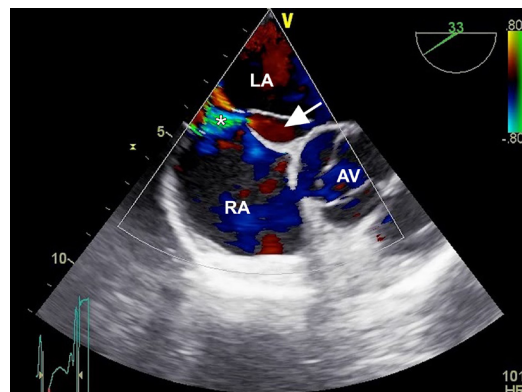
Two-dimensional transesophageal echocardiogram in color-flow Doppler mode (midesophageal short-axis view at aortic valve [AV] level) shows flow from the interatrial chamber (arrow) to the right atrium (RA) through a patent foramen ovale (asterisk).
